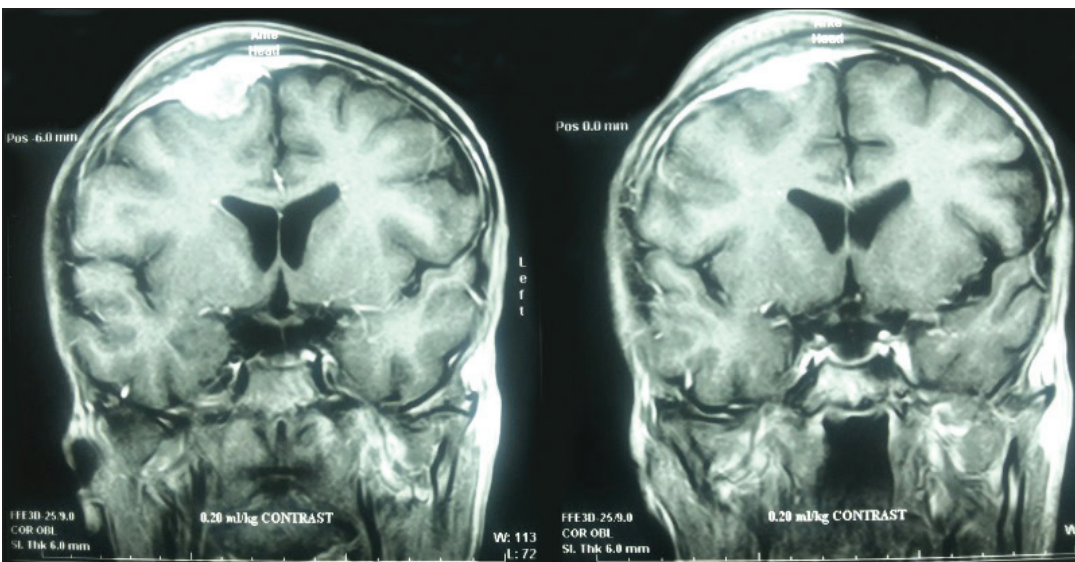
Coronal T1 weighted MRI from “Case 2” showing a parasagittal lesion related to the dura and measuring 3×2×2 cm in the right frontal regions with homogenous contrast enhancement.
